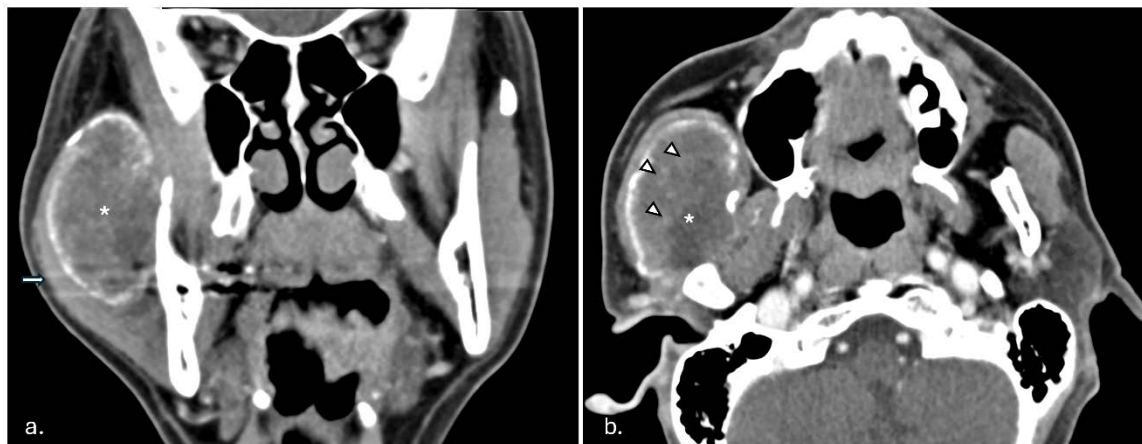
Contrast-enhanced CT (venous phase, soft tissue window) of a 58 year-old man with a right cheek mass; a) A mass (*) with internal and peripheral calcifications is seen within the right masticator space with lateral displacement of the right masseter muscle (arrow); b) The internal calcified matrix of the mass (*) shows configurations reminiscent of ring and arc calcifications (arrowheads).
